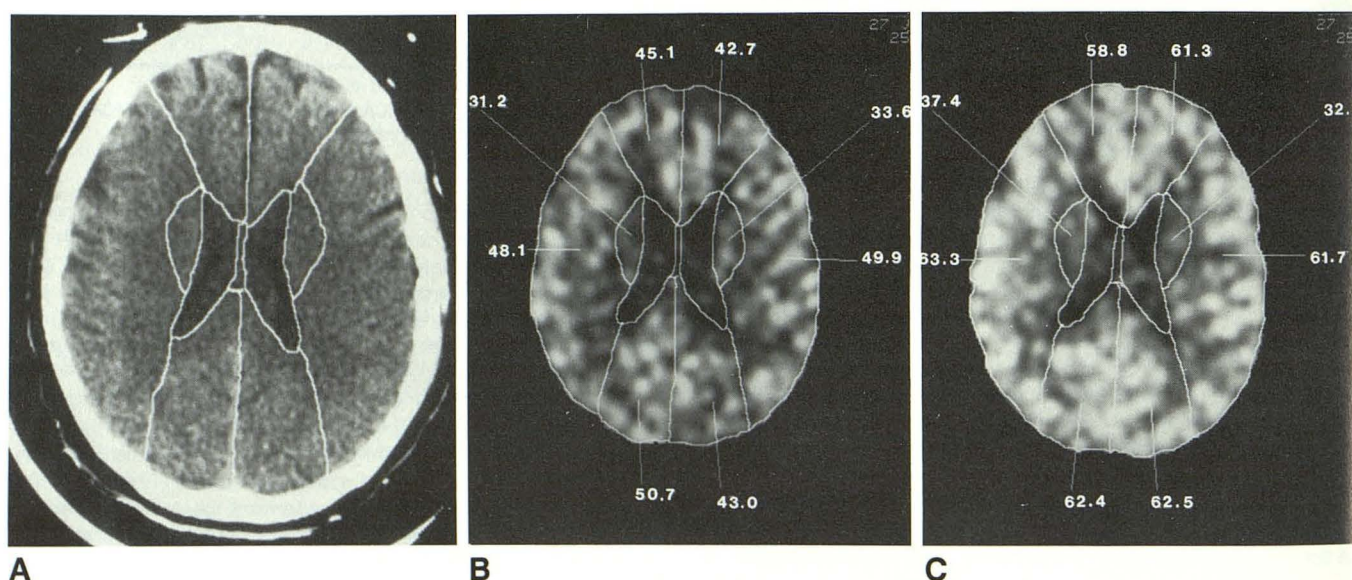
A–C, Case 26. Xe/CT scans demonstrate a representative type I normal scan series.
